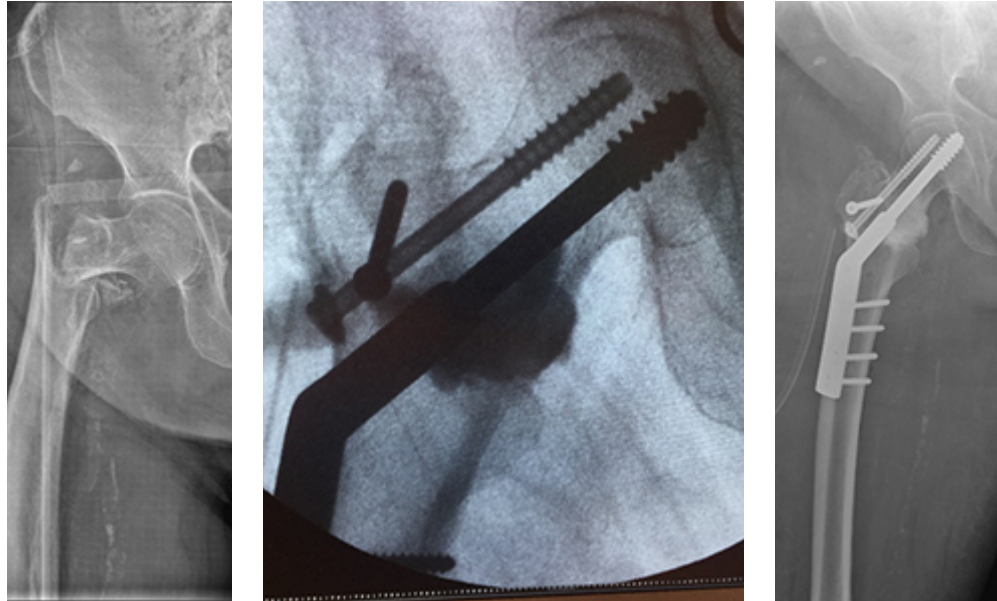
X-ray of 83 years old female patient with intertrochanteric fracture in the right hip (Fig. 6a). Perioperative fluoroscopy, injection of vancomycin containing bone substitute (Fig. 6b). X-ray of the first postoperative day (Fig. 6c).
